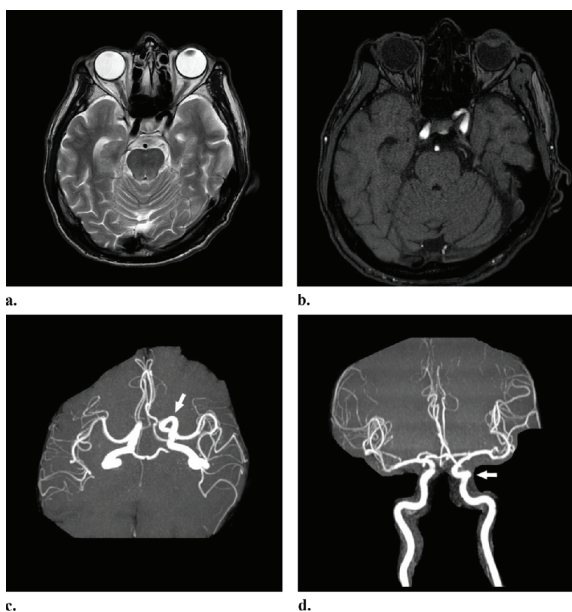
The axial T2-weighted image shows a signal void of both ICAs, (a) axial three-dimensional (3D) time-of-flight [TOF] MRA image also confirmed that the lesion in concern to be the tortuous left ICA, (b) 3D reconstructed TOF MRA, (c, d) indicates elongation and tortuosity in the horizontal orientation of the left cavernous ICA with an exaggerated loop at its anterior aspect (solid white arrows).
